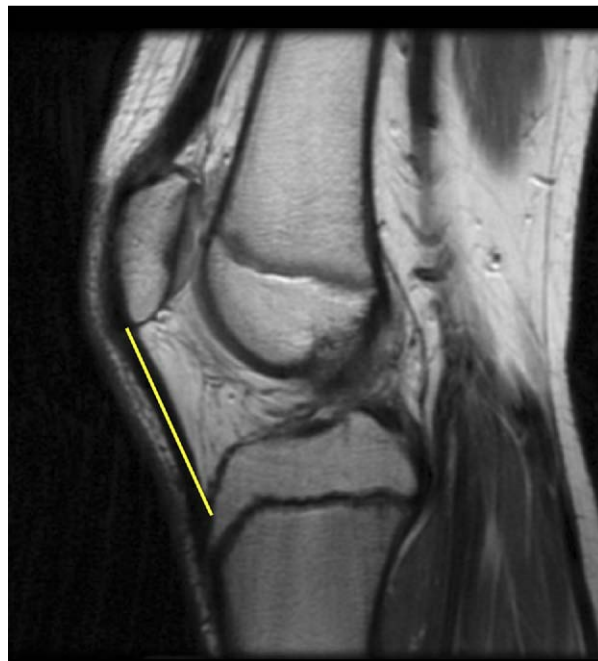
A T1-weighted midsagittal MRI scan showing measurement of patellar tendon length. Distance was measured from the inferior pole of the patella to the tibial tubercle (line).
